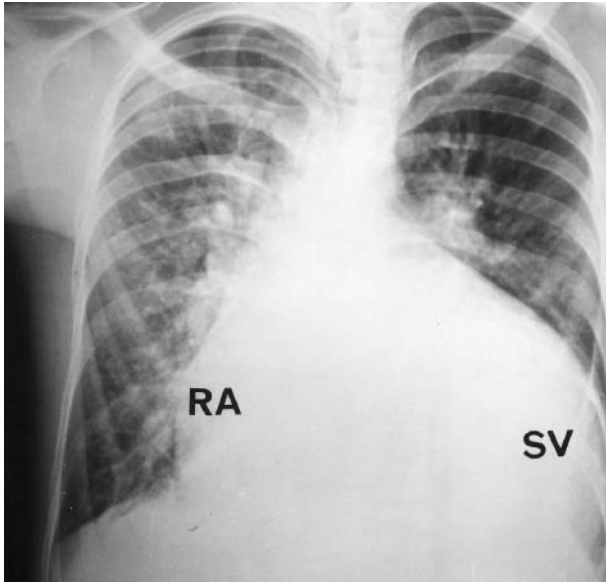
X-ray from a seven-year-old male with a single morphologic left ventricle, a noninverted outlet chamber, and pulmonary vascular disease. The vascular pedicle is narrow because the outlet chamber is located at the right basal aspect of the heart in the noninverted position, and the posterior pulmonary trunk is not border forming. The right atrium (RA) is enlarged, and the single ventricle (SV) is strikingly dilated. There is marked pulmonary venous congestion (failure of the single ventricle) typically manifested by prominence of upper lobe vascularity and obliteration of the hilar angle between the right upper lobe pulmonary vein and the right lower pulmonary artery.
